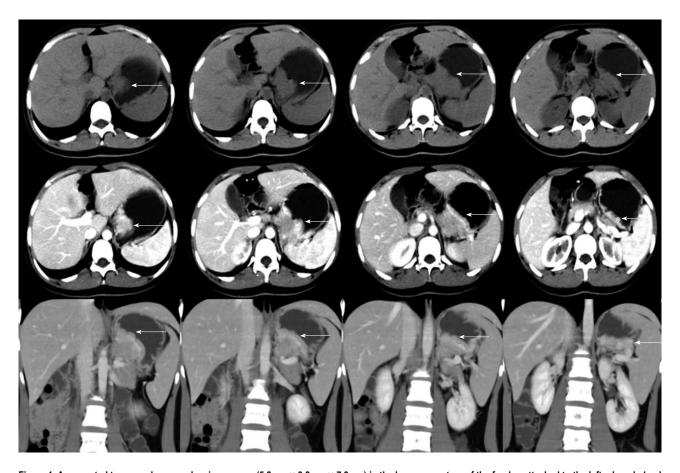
A computed tomography scan showing a mass (5.8 cm \times 3.8 cm \times 7.9 cm) in the lesser curvature of the fundus attached to the left adrenal gland with obscure boundaries (white arrows).
